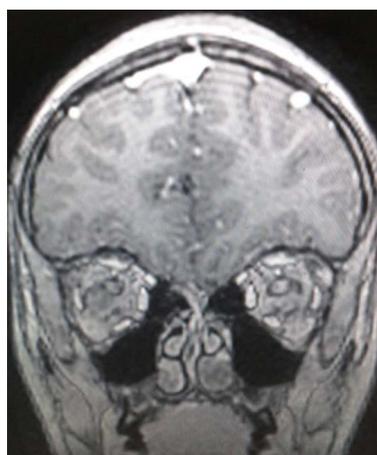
T1-weighted thin slice MRI of the brain with gadolinium injection showing infiltration of the left optic nerve (in favour of left optic neuritis).
